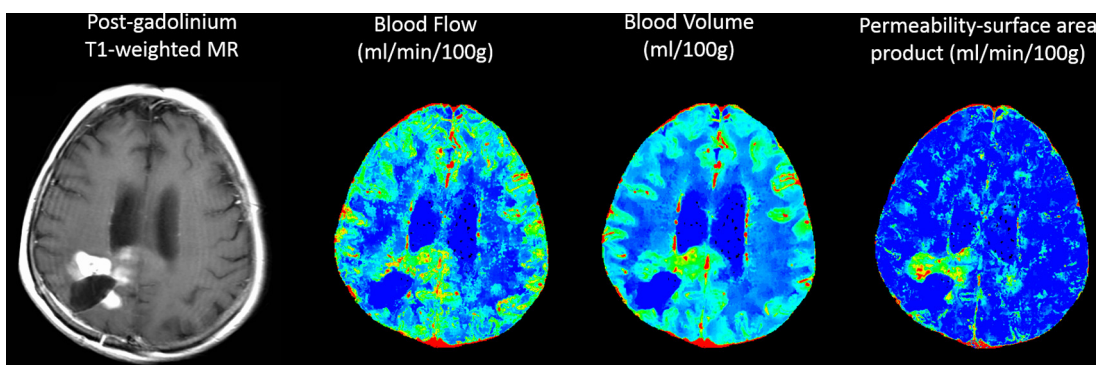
A patient who was previously treated for a glioblastoma multiforme shows a progressive enhancing lesion (T1-weighted MR) with high blood flow (BF), blood volume (BV), and permeability-surface area product (PS) suggesting progressive tumor around the surgical cavity at 6 months post-radiotherapy.
